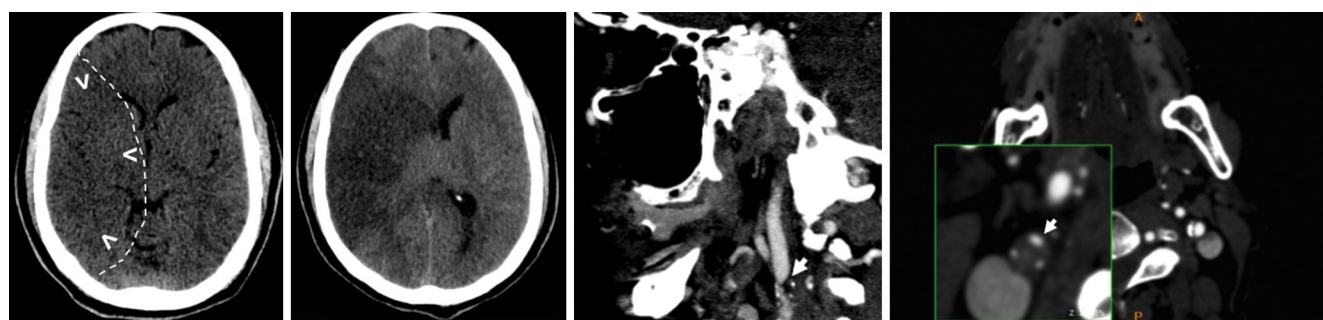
A 56-year-old man presented within 60 minutes of a left hemiplegia. (A) Initial non-contrast CT with subtle hypoattenuating area in the MCA territory (arrowheads). Dotted line demonstrated a more extensive ischemic area according to the follow-up exam; (B) Follow-up imaging after 3 days demonstrated hypoattenuation in almost complete right MCA territory, which was compatible with brain ischemia as a result of artery-to-artery embolism; (C) Sagittal CTA MIP image demonstrated a heterogeneous plaque (arrow) determining severe luminal obstruction (90%); and (D) Axial imaging confirming the severe obstruction determined by heterogeneous plaque.
